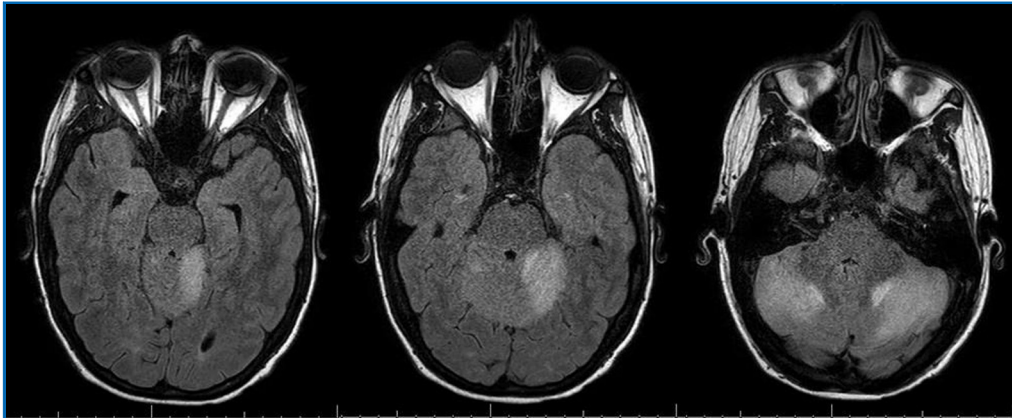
Axial T2 FLAIR MRI of patient on day 6 of hospitalization and day 4 of dexamethasone therapy. FLAIR = fluid-attenuated inversion recovery; MRI = magnetic resonance imaging.
